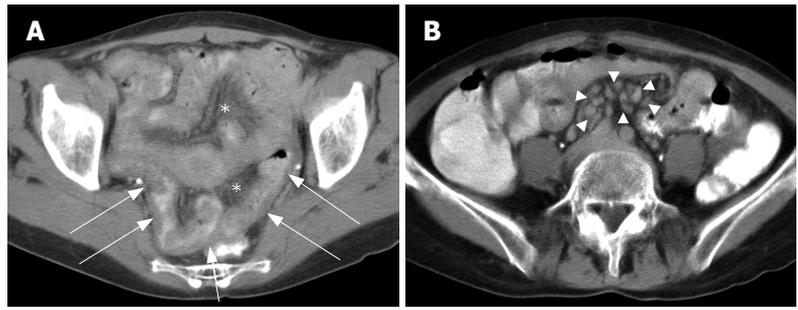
Axial CT image of a patient with RCD type I demonstrates (A) multiple small lymph nodes (arrowheads) and (B) thickening of the ileal wall (arrows) and infiltration of the mesenteric fat (*).
